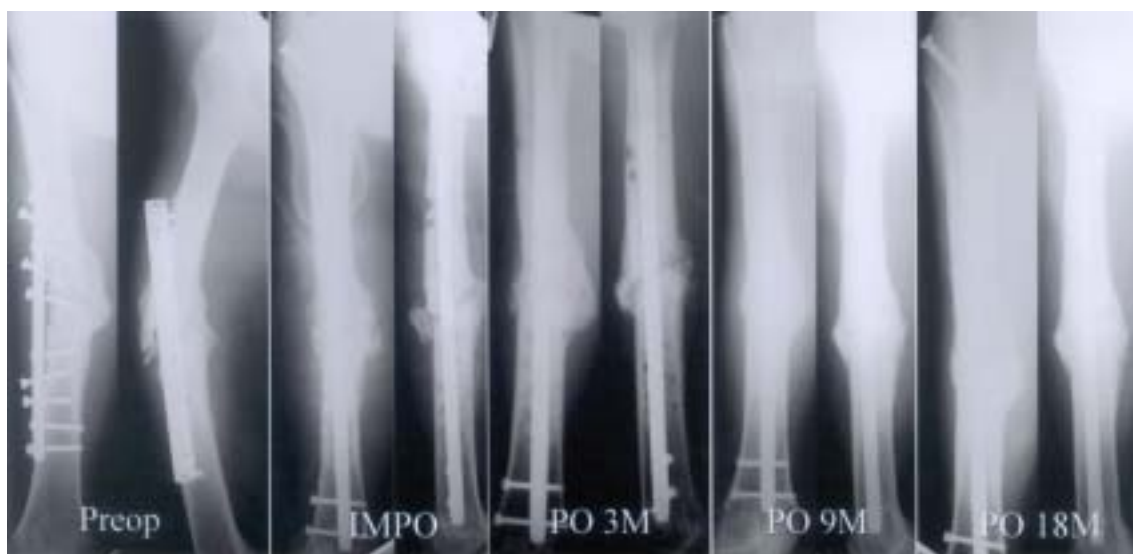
This 26 year-old male patient had undergone plate and screw surgery for the closed fracture of femur mid-shaft in a local clinic, which resulted in infectious osteomyelitis with draining sinus and severe angulation deformity. *Pseudomonas aeruginosa* was grown in wound culture and initial CRP of 7.0 mg/dL was controlled to 1.7 mg/dL before surgery. At postoperative 12 months, she underwent vancomycin-cement coated unreamed intramedullary nailing, whose femur gained radiographically complete bony union at 12 months, and whose implant was removed at 25 months postoperatively. We allowed partial weight bearing at postoperative 6 weeks, full weight bearing at postoperative 3 months.
